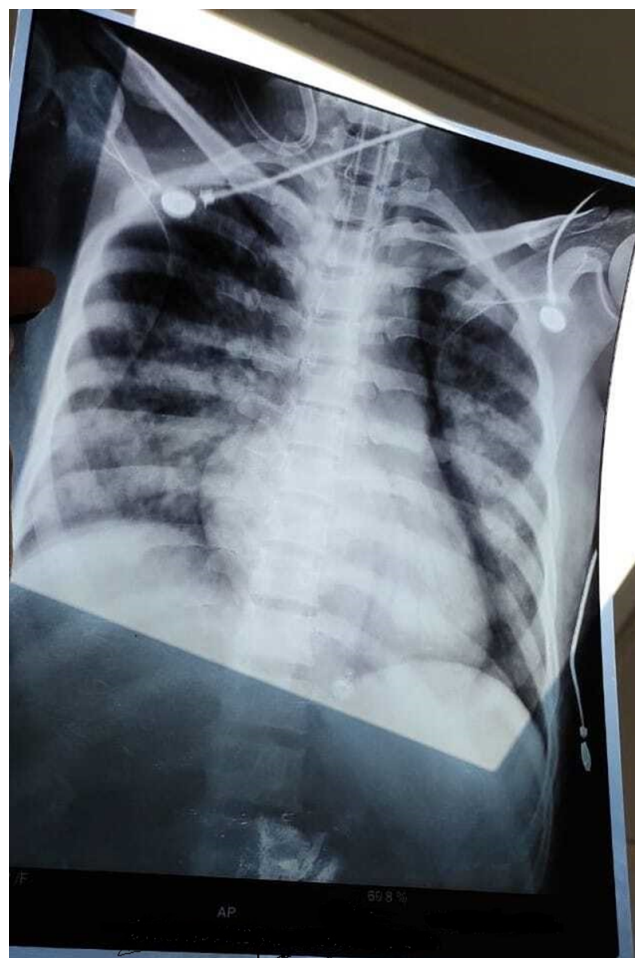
Antero-posterior chest X-ray showing bilateral diffuse reticular opacities suggestive of ARDS
